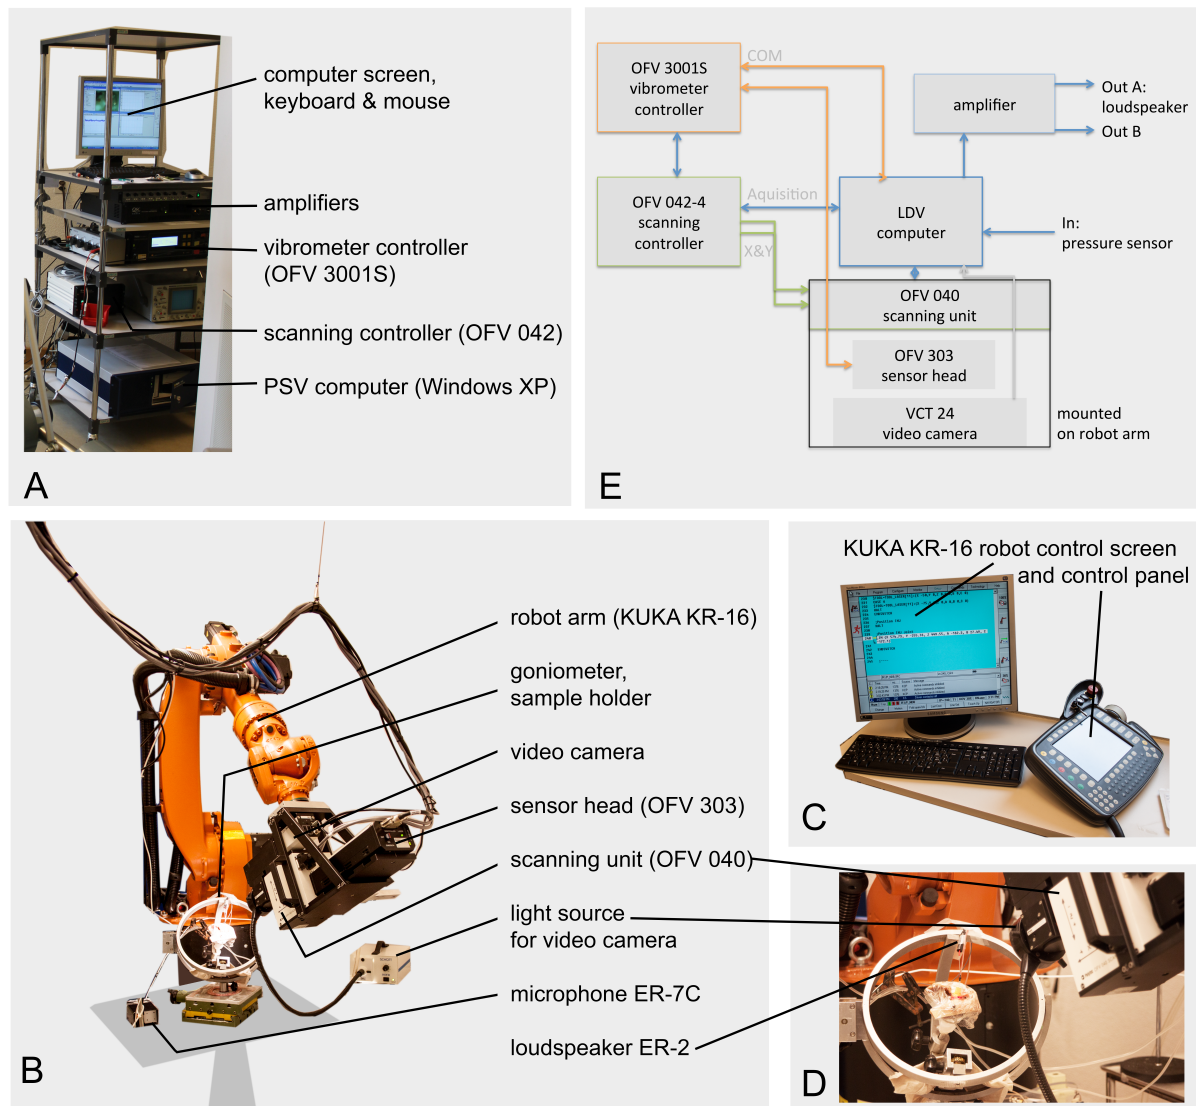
Setup of the scanning laser Doppler vibrometer (SLDV) system PSV-200-1 from Polytec GmbH (Waldbronn, Germany).
